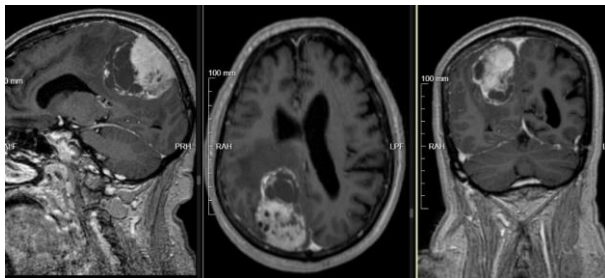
Pre-op MRI cystic meningioma classified by Nauta as type III.
